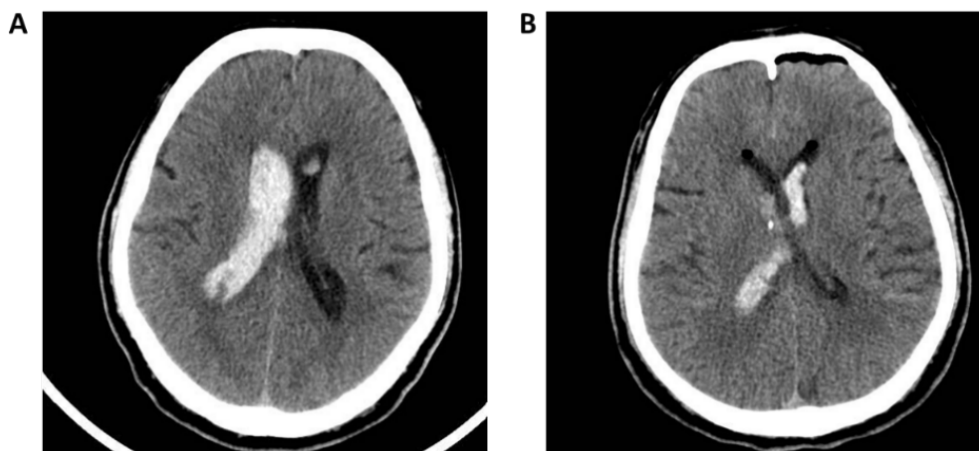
Head CT scans of the patient after admission in hospital. (A). Head CT showing a amount of blood, effusion, and swelling of the surrounding soft tissue in the right lateral ventricle on September 26. (B). Head CT after intracerebral hemorrhage surgery on September 27.
